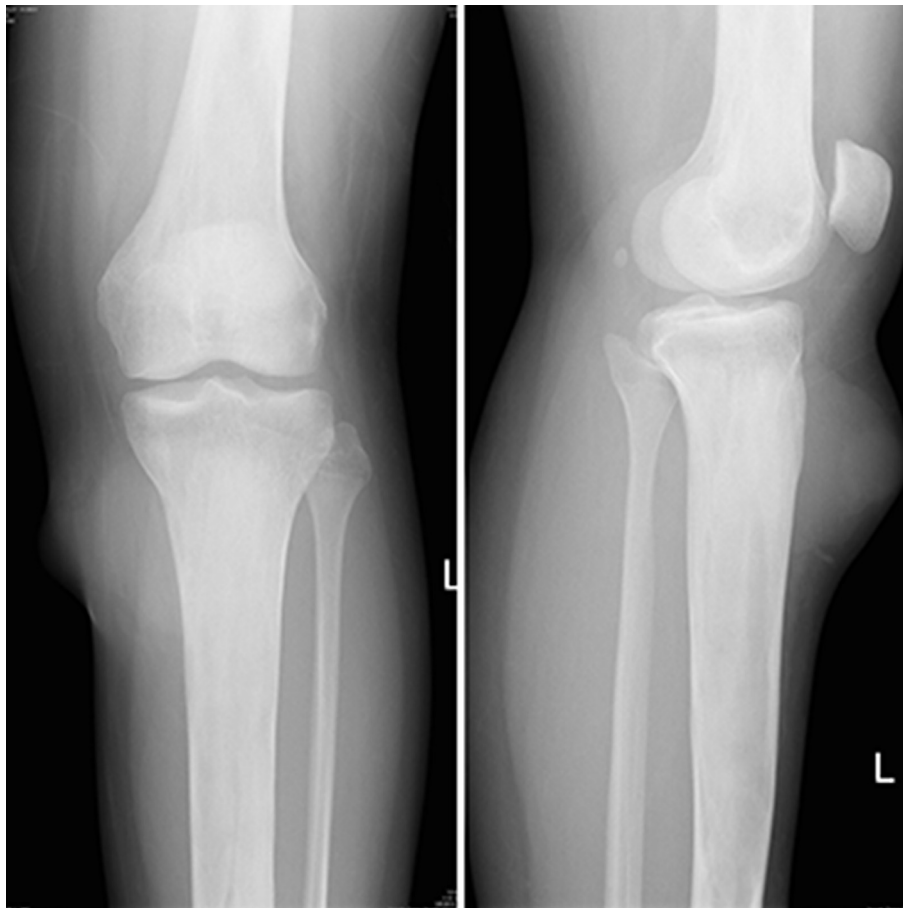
X-ray of the left leg showed non-specific mild increased bone density, subtle irregular lucency and mild expansion with thickening of the cortices.
